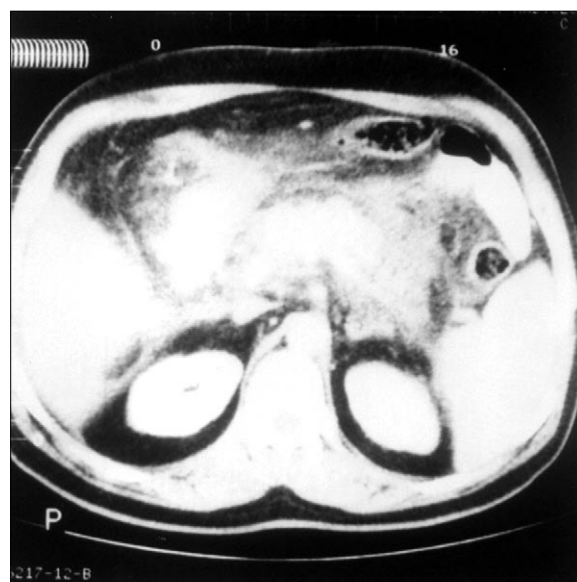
Abdominal CT image of the patient revealing acute pancreatitis by enlarged pancreas, peripancreatic fluid collection, and hypodense necrotic areas in the head of the pancreas.
